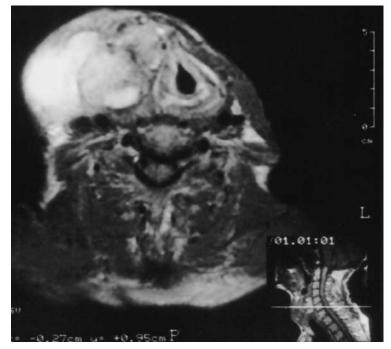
Magnetic resonance image of neck mass showing tracheal deviation and anatomic relationships.
